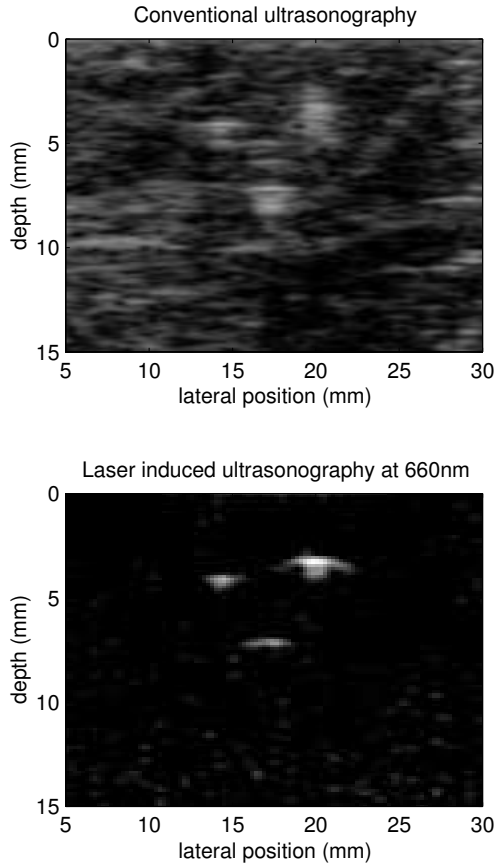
Experimental setup validation. Conventional and laser-induced images of a beefsteak containing three pencil leads (bright spots in the images). brightness is proportional to the signal intensities in both picture. Identical receiver settings were used to acquire these unaveraged images. Because of the strong optical absorption, the pencil leads show superior contrast on the laser-induced image compared to the conventional ultrasound image. The positions of the samples match on both images.
